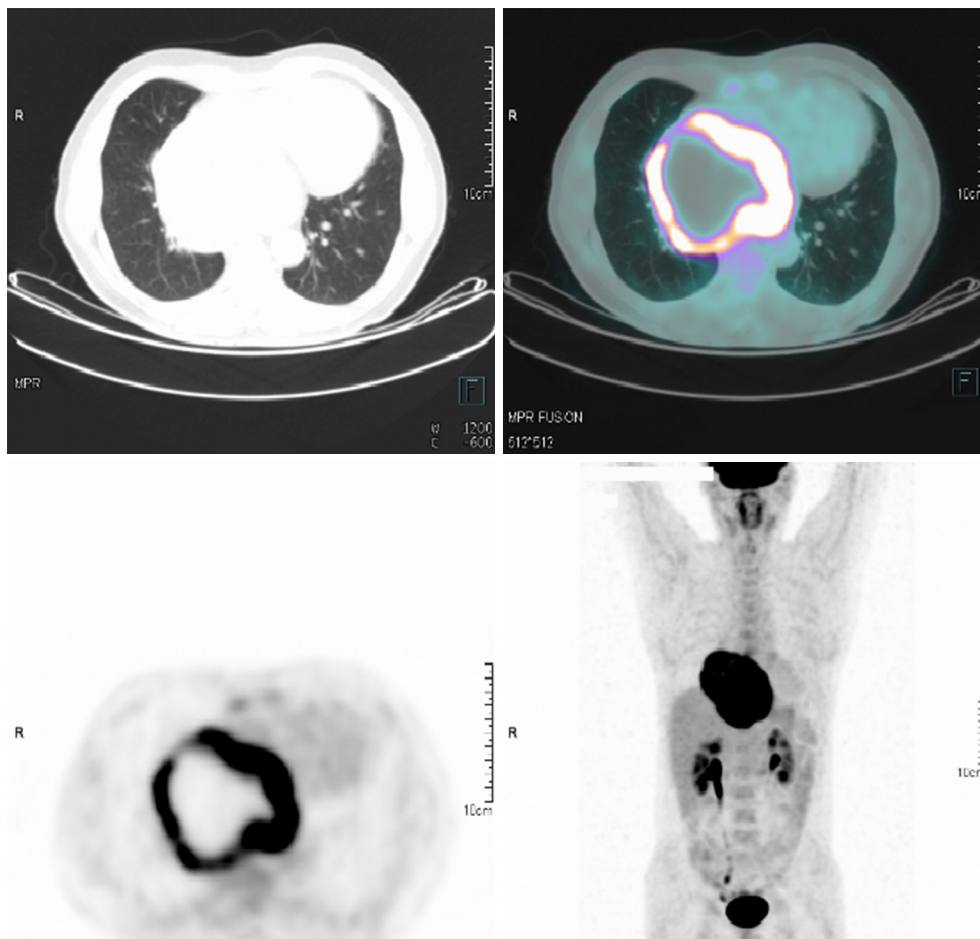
Positron emission tomography (PET)-CT in diagnosis confirming the giant mass with an increased metabolic activity in the posterior mediastinum. CT, computed tomography.
